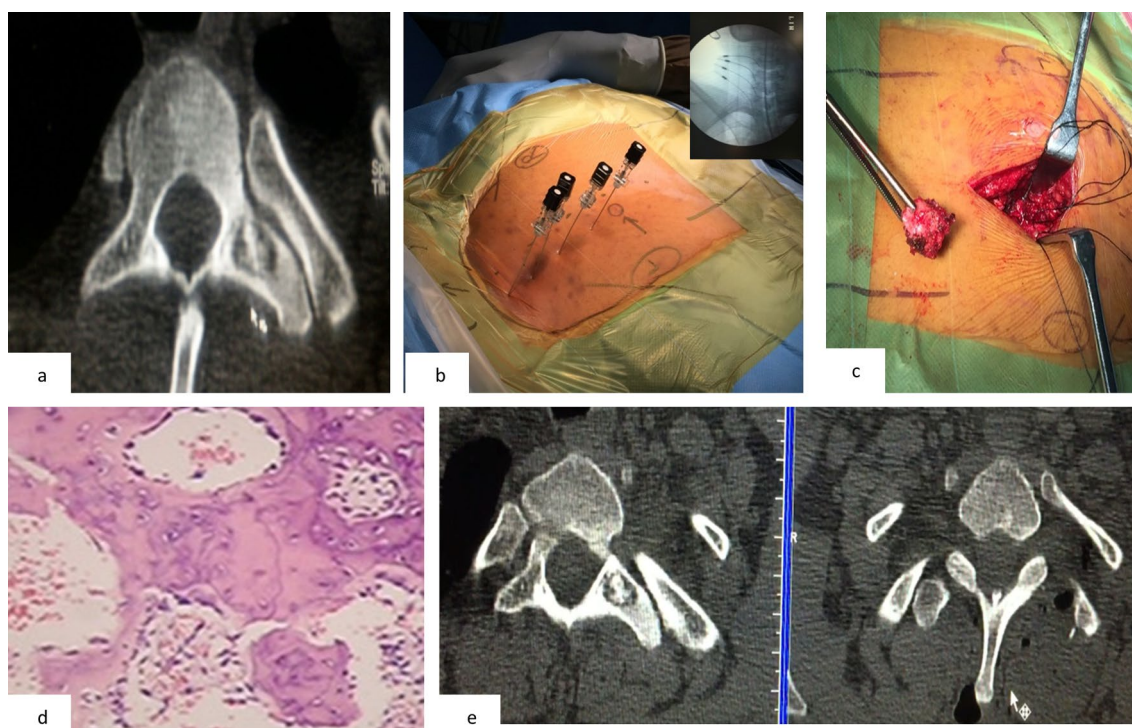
Case 2 a Axial CT showing D2 vertebral transverse process lytic and central sclerotic lesion, b preoperative CT followed by intraoperative C arm localization of D2 level, c excised tumor mass, d HPE slide confirming osteoblastoma, e pre- and post-operative comparative axial CT cut showing complete removal of tumor
